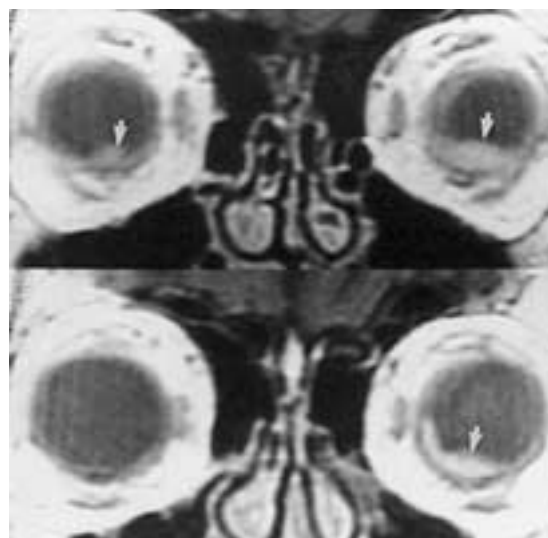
Uveal lymphoma. Enhanced T2-weighted MR images showing bilateral, intraocular, irregular enhanced masses (*arrows*). (Courtesy of M.F. Mafee, MD, FACR, Chicago.)
